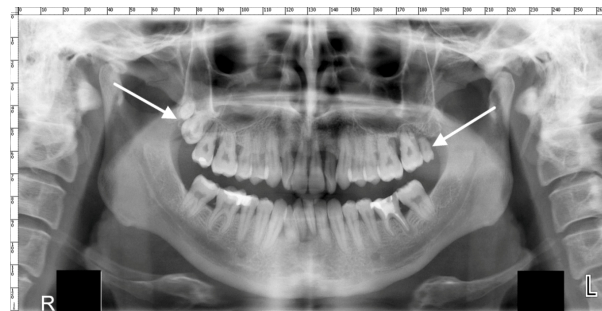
Panoramic radiological investigation showing the presence of two distomolars bilaterally situated in the upper jaw. R: Right; L: Left.
